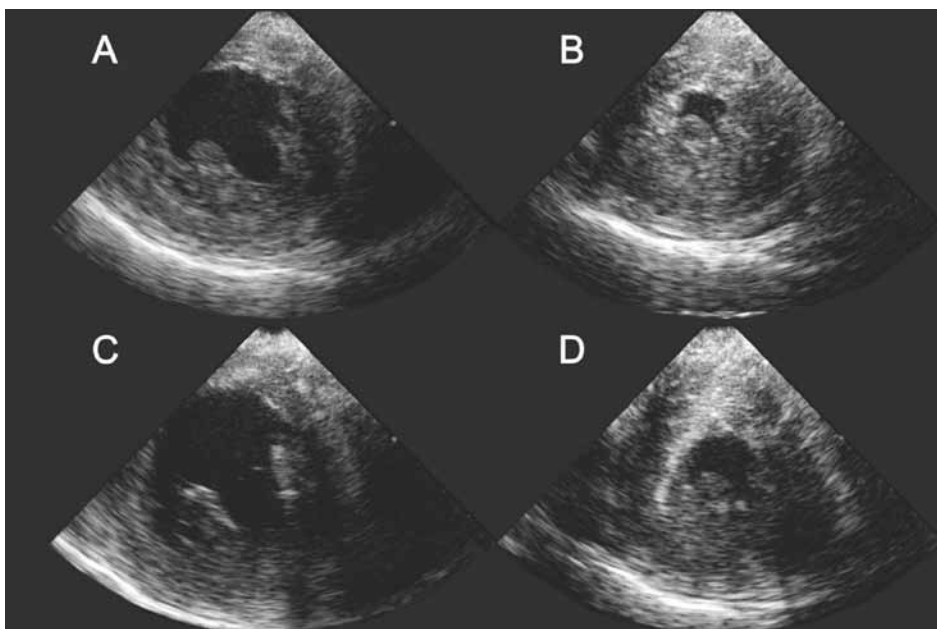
Effect of Impella support on LV volumes in patient#12, investigated by intracardiac echocardiographic AcuNav catheter. Left ventricle short axis views during diastolic and systolic phases at baseline (A, B) and after activating the Impella support at 43000 rpm.(C, D).
